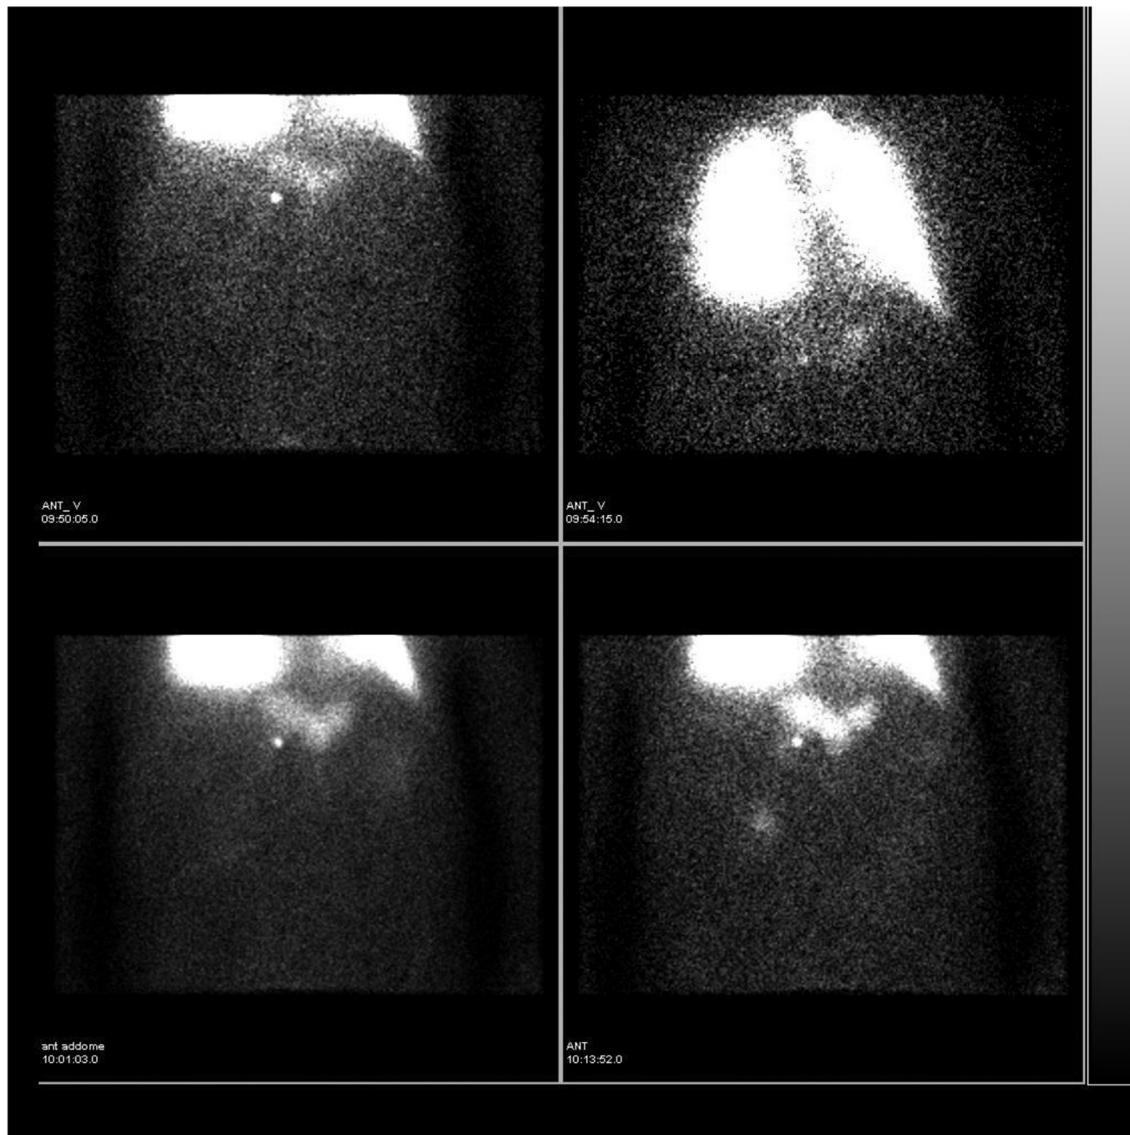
Pulmonary scintigraphy demonstrated radiolabelled air in the stomach.
